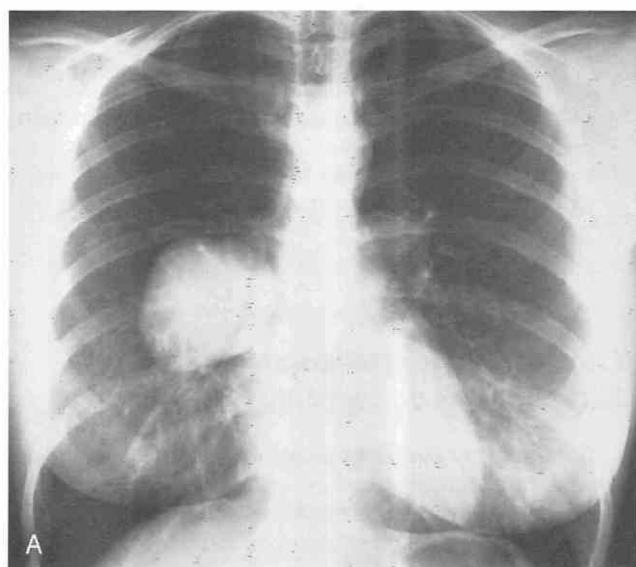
Pulmonary blastoma seen as a lobular pulmonary mass. *A*, Posteroanterior chest radiograph shows a sharply margined, lobular mass in the right upper lobe. *B*, CT confirms the lung mass and shows heterogeneous attenuation consistent with necrosis.
